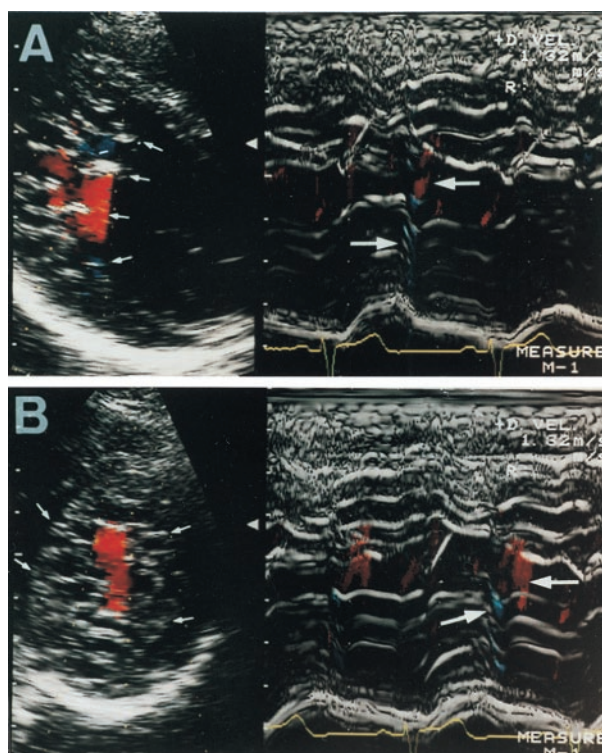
A representative echocardiogram in a patient with INVM (case 3, Table 1). Two-dimensional echocardiogram demonstrates numerous prominent trabeculations (small white arrows) and intertrabecular recesses in the apex and free wall of the left ventricle in the parasternal long-axis view (A) and in the parasternal short-axis view (B). Color Doppler and M-mode echocardiogram show typical forward (red color, white arrow) and reversed flow (blue color, white arrow) between prominent trabeculations during the cardiac cycle.
